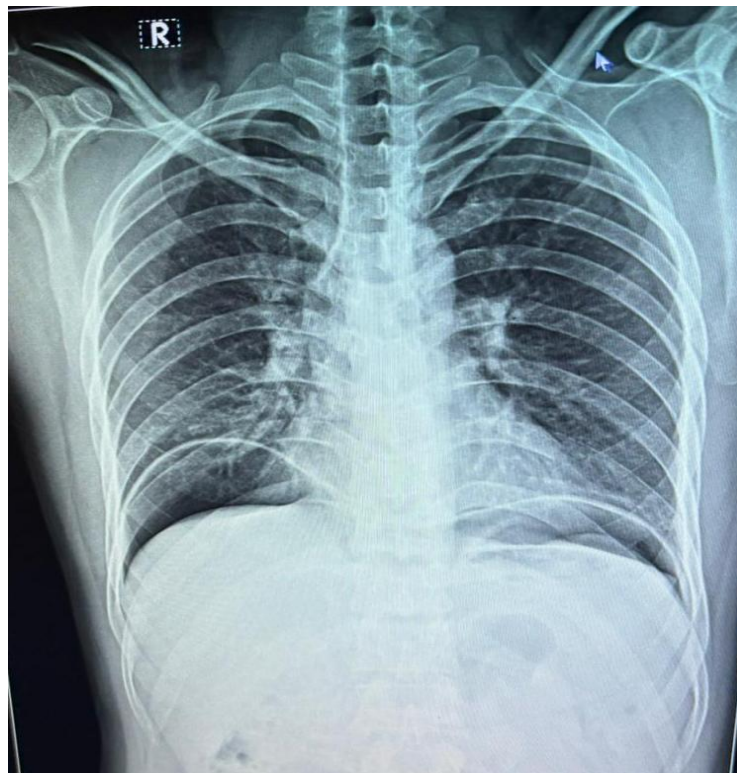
Radiological findings: plain radiograph demonstrating free intraperitoneal gas (pneumoperitoneum) in a patient with perforation peritonitis.
